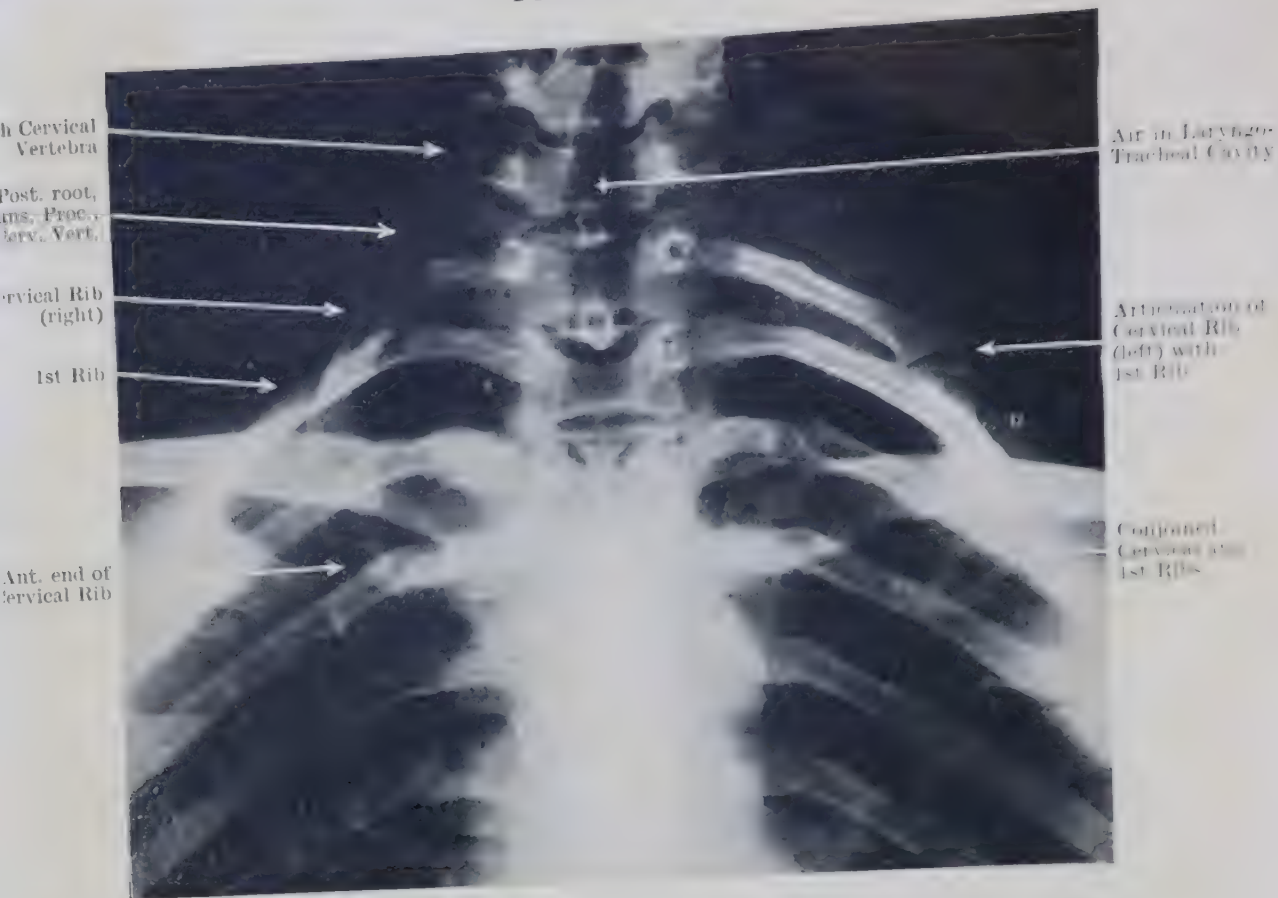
RADIOGRAPH OF CERVICO-THORACIC REGION OF WOMAN AGED 35, SHOWING A PAIR OF WELL-DEVELOPED CERVICAL RIBS.
